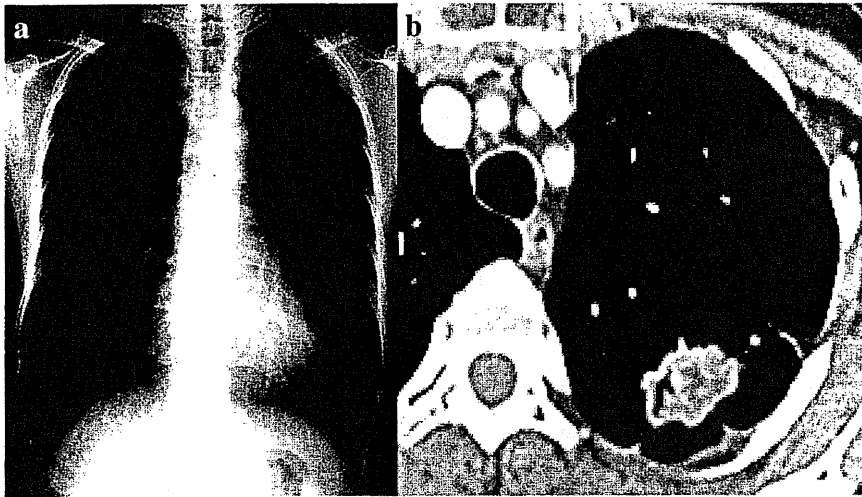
a: A chest radiograph showed a tumor shadow in the left upper lung field. b: Chest CT showed a tumor shadow with pleural indentation in the left S<sup>1+2</sup>.
